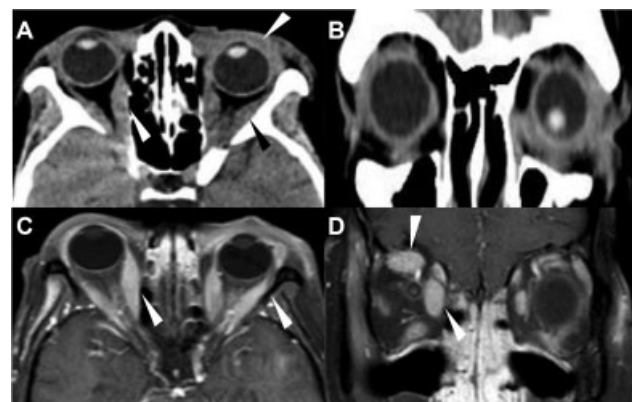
Orbital lymphoma. A and B – Computed tomography without contrast shows left eyelid involvement with thickening of the bilateral extrinsic musculature (arrows). C and D – T1 postcontrast shows intense homogeneous contrast enhancement of the bilateral extrinsic musculature (arrows).
